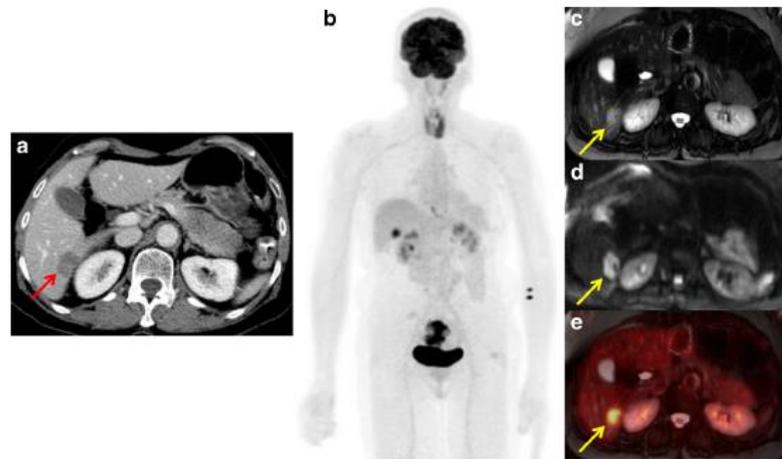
PET/MRI is similar to CS in a 63-year-old female patient with primary rectal cancer without EMVL. A single metastasis was observed on abdominal ceCT (a; red arrow) as well as PET/MRI with intermediate
